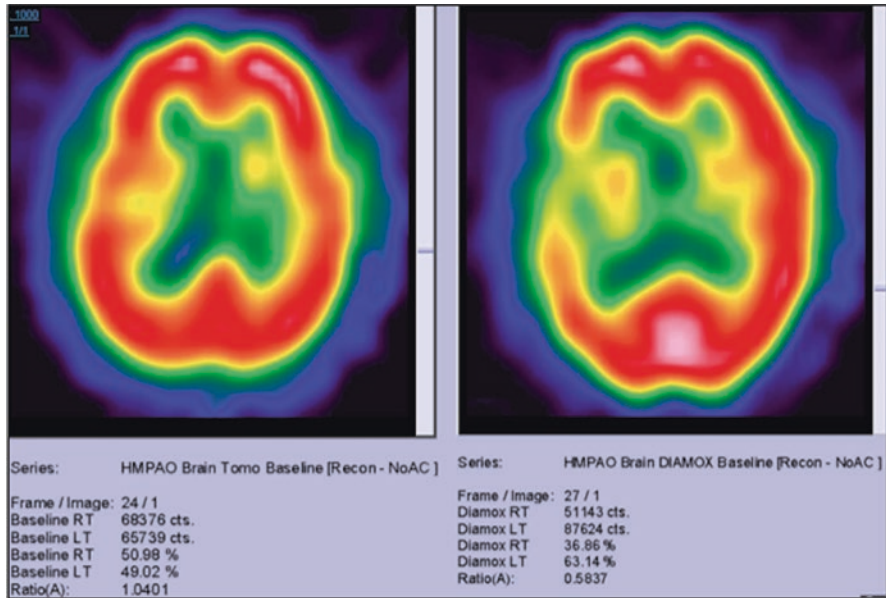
Acetazolamide-challenged HMPAO-SPECT. Baseline SPECT shows nearly symmetrical metabolic perfusion in both hemispheres (right 50.98%, left 49.02%). However, after acetazolamide challenge, markedly reduced metabolic perfusion is noted in the right hemisphere (right 36.86%, left 63.14%; net perfusion deficit = 28.24%). (Courtesy: Vijay Sharma, MD)
